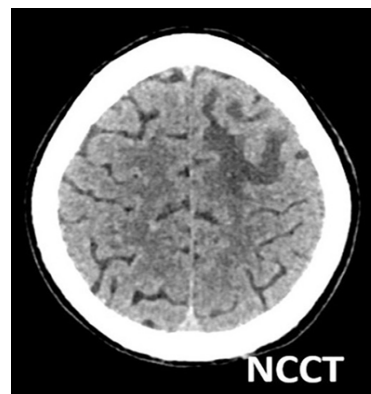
Axial Non contrast CT image of brain of the patient shows sulcal hypodensity in the left frontal region.
